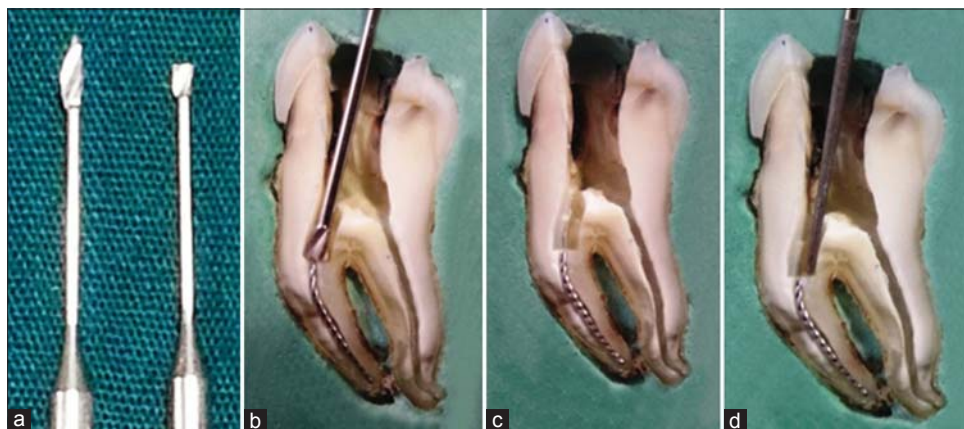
(a) Runaway gates, (b) coronal and radicular access followed by preparation of staging platform, (c) staging platform complete, (d) ultrasonic tip placed on the platform
